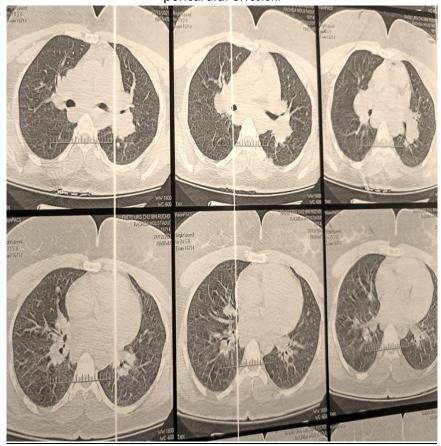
Chest CT scan on the parenchymal windows noticed the absence of nodules or micronodules or septal thickening.
